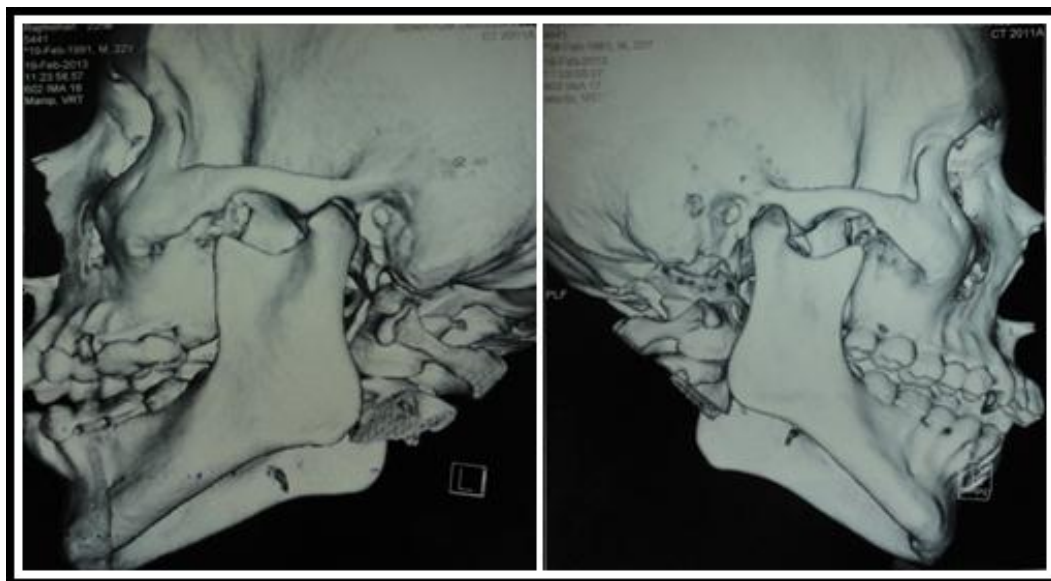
Pre operative diagnostic CT images of the Left and Right TMJ.
